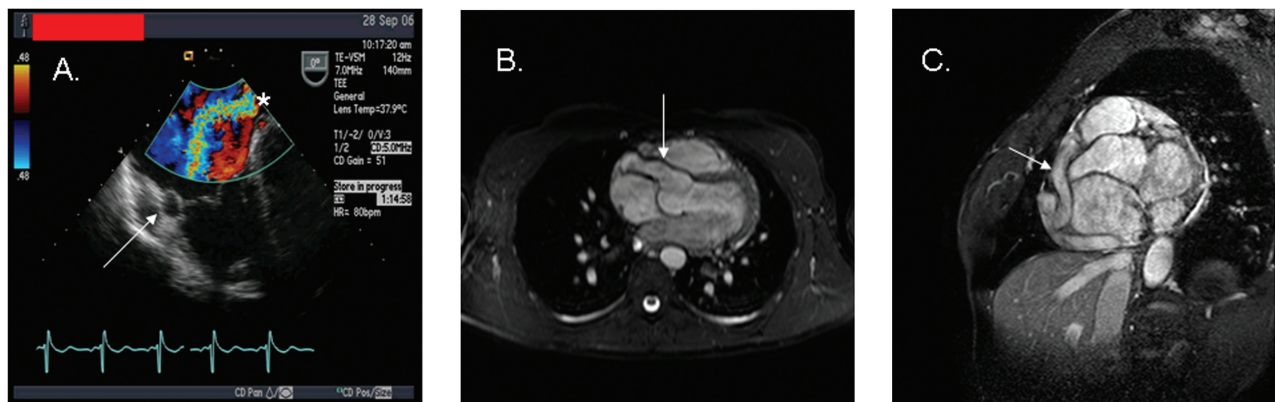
Transesophageal echocardiogram (A) and cardiac magnetic resonance imaging (B, C) demonstrating a markedly enlarged and tortuous right coronary artery (RCA). Arrows denote RCA at its origin from the aortic root (B) and as it travels through the atrioventricular groove (A, C). The (*) denotes turbulent flow traveling from the coronary sinus to the right atrium.
